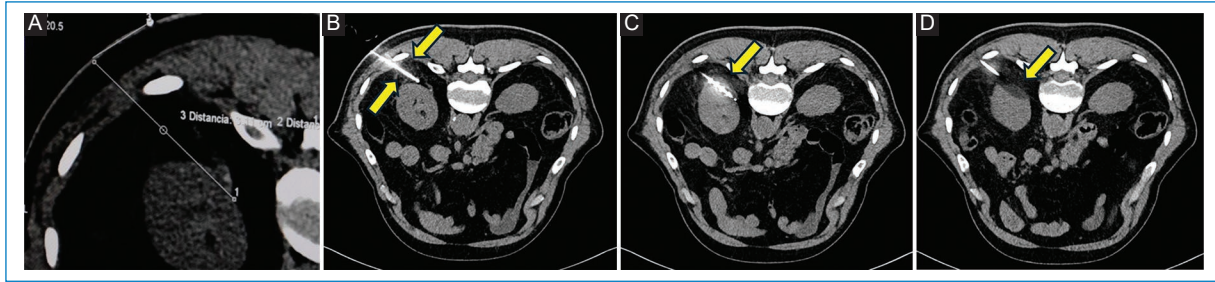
Axial computed tomography slices, in prone position. A: pre-procedure planning. B: positioning of the IceRod™ cryoablation needle, left posterior approach. C: final positioning control prior to the start of cryoablation cycles. D: hypodense image corresponding to the "ice ball" covering 100% of the tumor.
